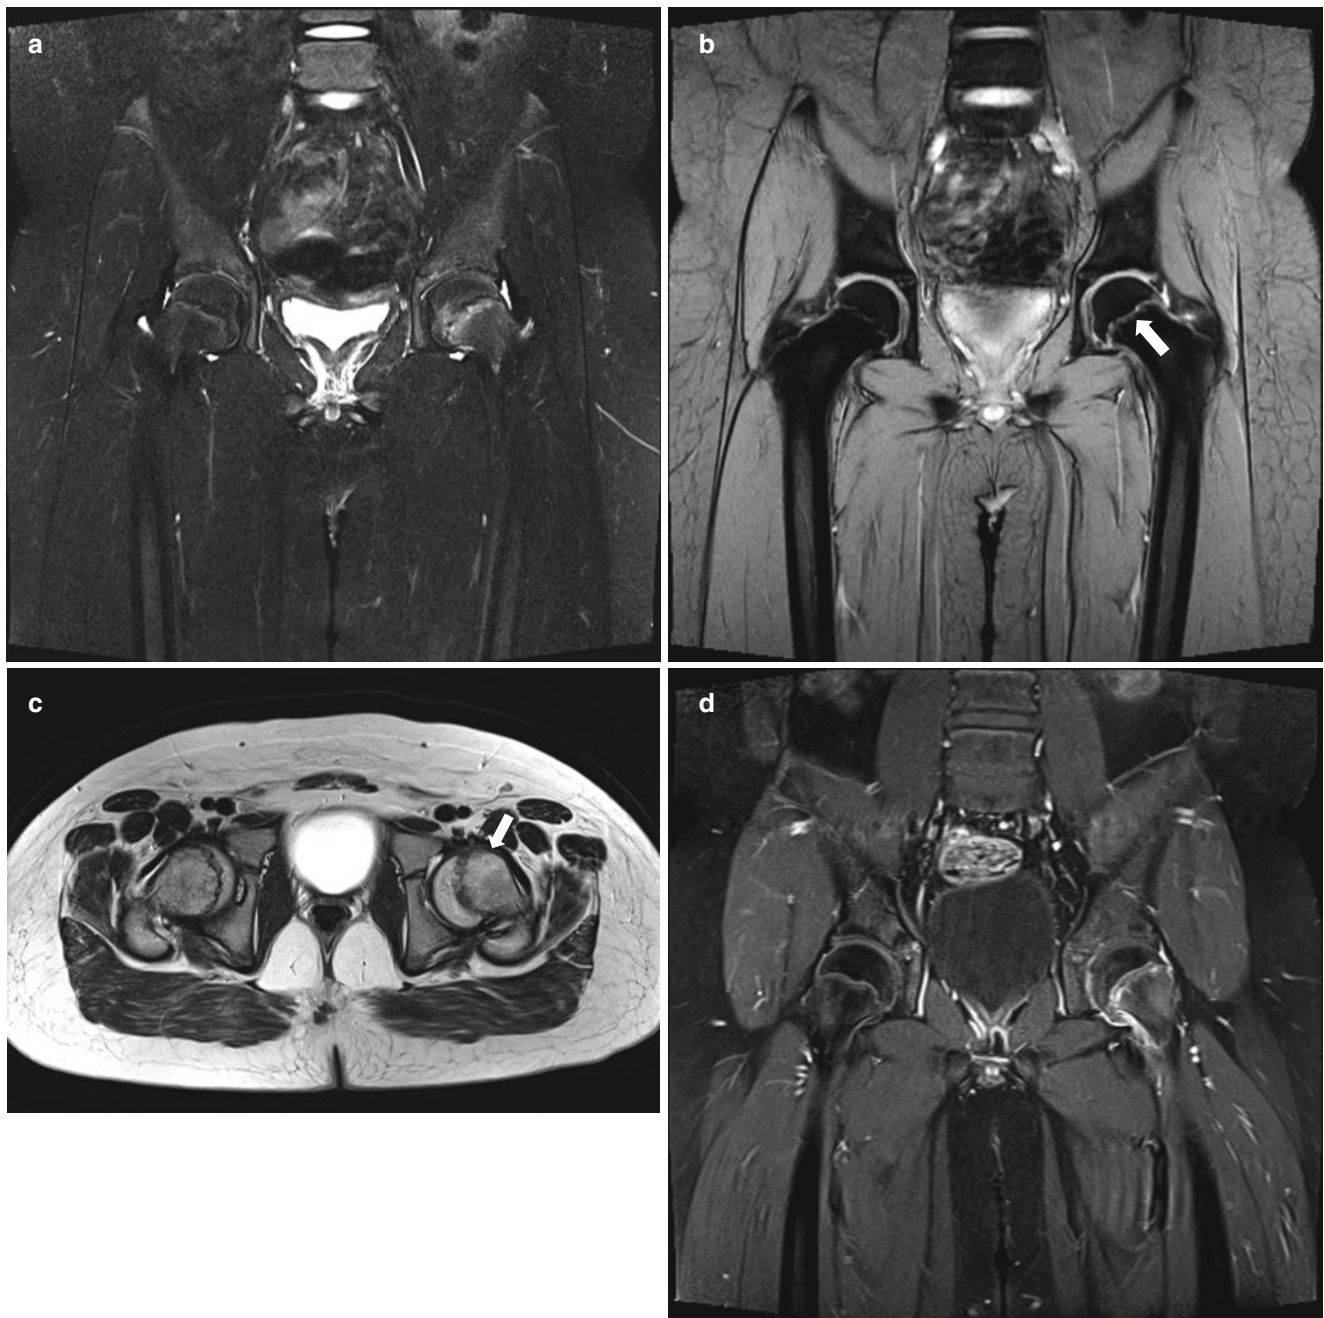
MRI appearance of slipped capital femoral epiphysis. (a) Coronal T2-weighted image demonstrates asymmetric widening of the left proximal femoral growth plate with mild metaphyseal and epiphyseal bone marrow edema. (b) Coronal gradient echo image clearly demonstrates asymmetric widening of the left proximal femoral
